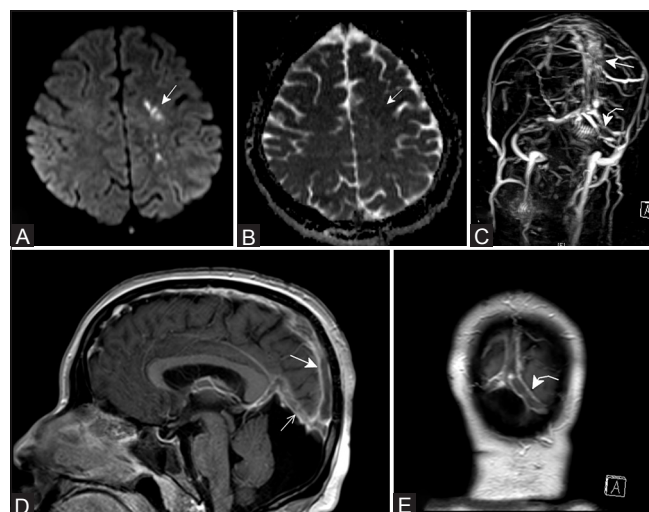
(A-E): MRI brain showing areas of restricted diffusion in deep white matter of bilateral frontal lobes (arrow) in both diffusion (A) and ADC maps (B) suggestive of infarcts. There is extensive subacute thrombosis of the entire superior sagittal sinus (straight arrow), both transverse sinuses (curved arrow), straight sinus (thin arrow), and multiple cortical veins in the MRV images (C-E)
